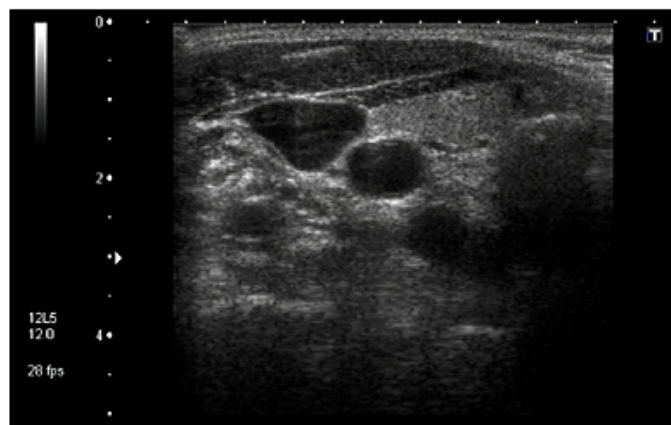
Neck ultrasound revealed a cystic mass measuring 3.0×1.5 cm on the right of neck.
